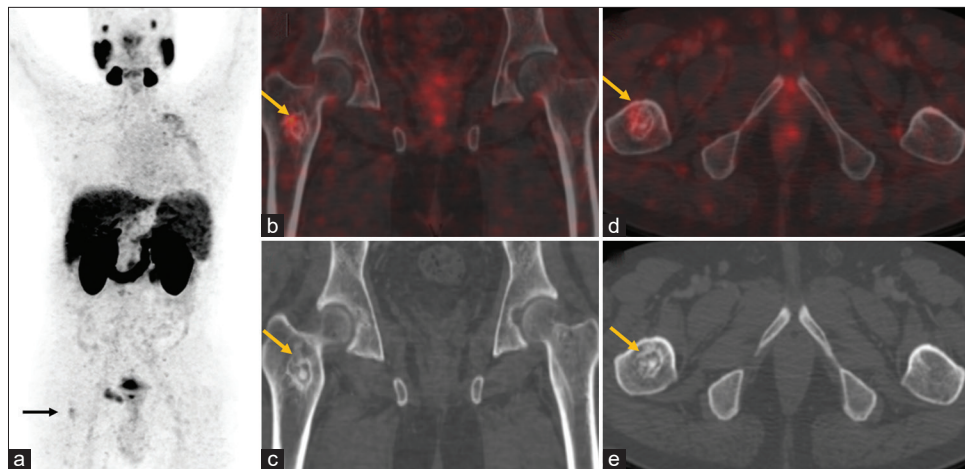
This is a case of a 56-year-old patient with adenocarcinoma prostate (Gleason score 4+5=9), post bilateral orchidectomy and TURP. 68Ga PSMA PET/CT scan was done for staging and MIP image (maximum intensity projection; a) shows focal low grade tracer uptake (SUVmax 2.67) in right femur (black arrow). The fused and CT images in coronal and axial planes show low grade uptake in a sclerotic focus surrounded by a well-defined sclerotic rim with intermittent osteolytic features. Radiologically, this lesion appears to be a benign skeletal lesion not otherwise specified (b-e; yellow arrows).
